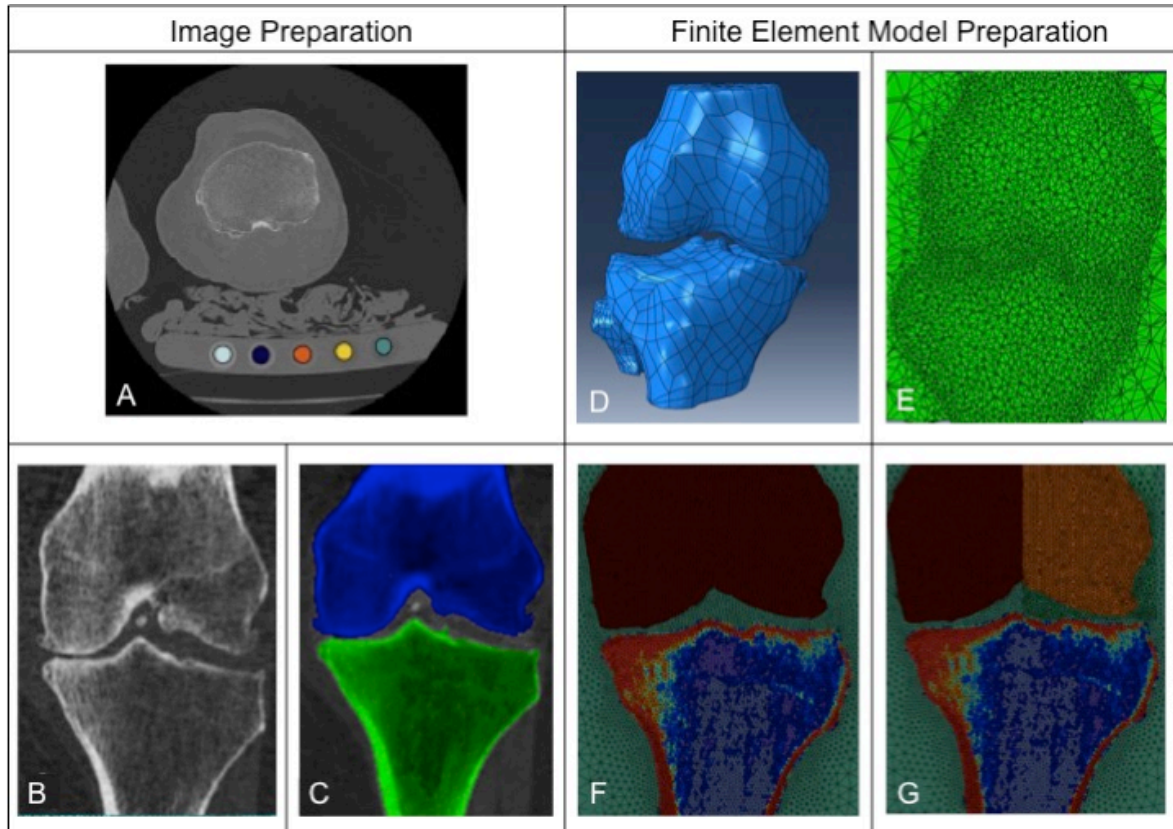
Process for developing subject-specific FE models. Grayscale Hounsfield units from CT images were converted to bone mineral density (BMD) values (A), serial images (B) were segmented (C) – coronal view of femur in blue and tibia in green – to create imaged volumes for each included bone. Imaged volumes were rendered and smoothed to create three-dimensional geometries (D), which were meshed with 10-node tetrahedral elements (E). All meshed models included the femur, tibia, and fibula (not pictured) within a cylinder representing surrounding soft tissue. BMD-based material properties were assigned and mapped to each model (F). To calculate lateral stiffness, the medial side was isolated from the model by assigning soft tissue material properties to the medial distal femur (G).
